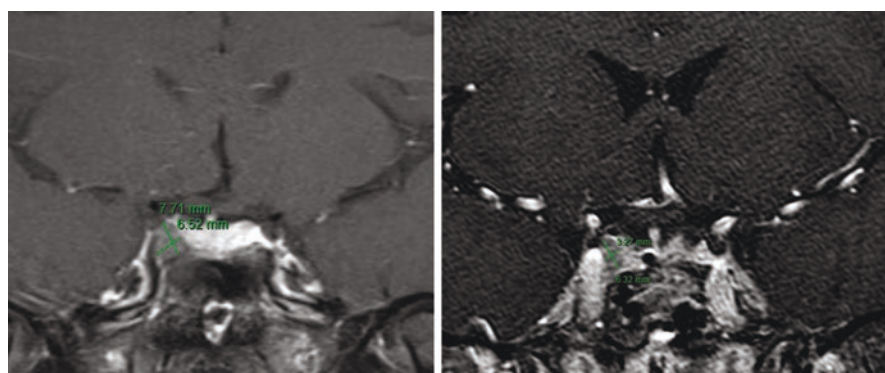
Coronal T1 spin echo MRI sequences after gadolinium demonstrate a hypo-intense right-sided lesion before surgery (left panel) and at the time of recurrence (right panel)
